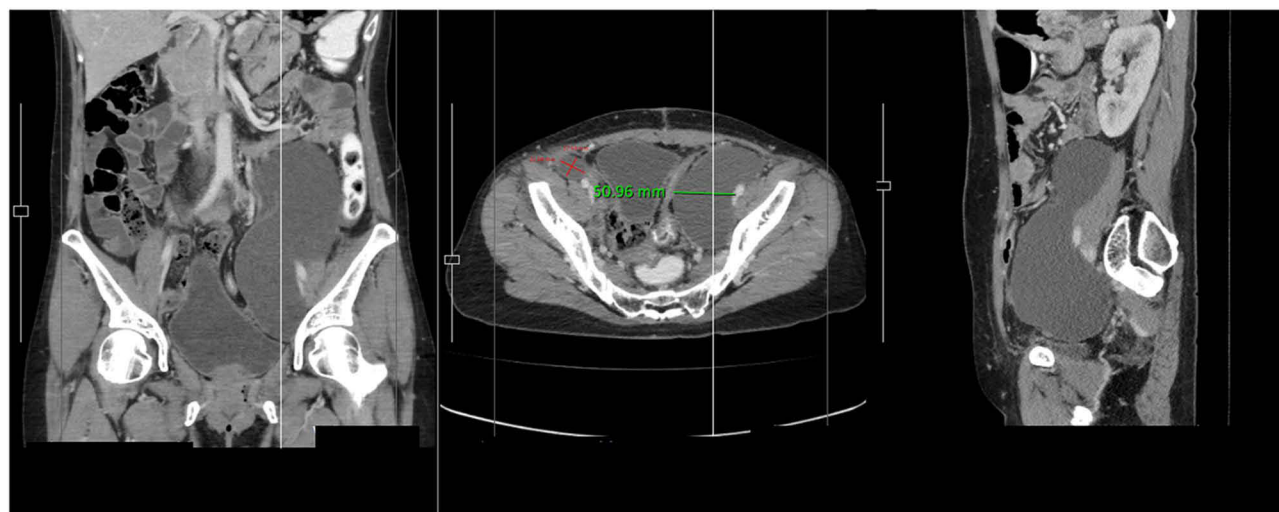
A $6.2 \times 7.8 \times 17.0$ cm thin-walled cystic lesion in the left abdomen (green-colored line), suggestive of a lymphocyst, was identified on CT scan. A smaller thin-walled cystic lesion was also noted on the right side (the intersecting red-colored lines forming a cross to measure width $\times$ length), measuring 2.20×1.75 cm.
